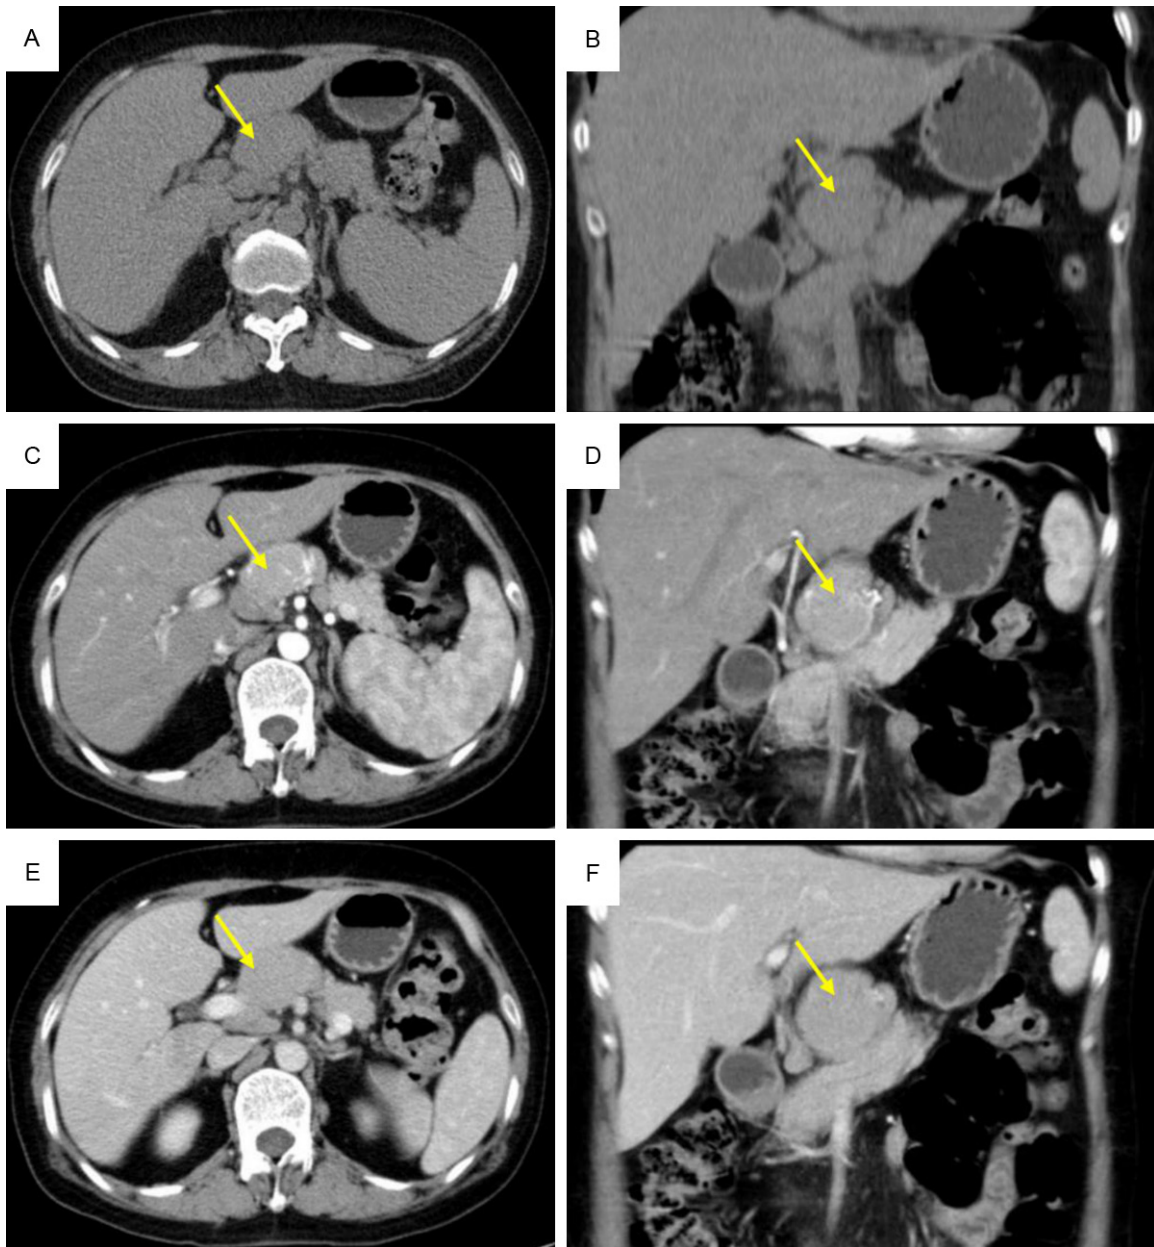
CT scans obtained before (A. Axial), (B. Coronal) and after (C. Axial), (D. Coronal) arterial phase; (E. Axial), (F. Coronal) venous phase injection of contrast medium show a well-circumscribed, round mass (yellow arrows) that appears intensely enhanced and the enhancement of blood vessels in the arterial phase with moderate washout in the venous phase.
